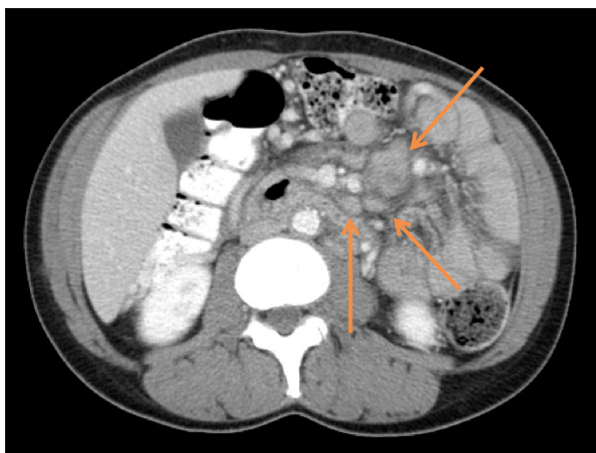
One week after start of treatment, Axial contrast-enhanced CT image at level of lower pole of kidneys, demonstrating sub-centimeter and enlarged mesenteric lymph nodes (arrows).
